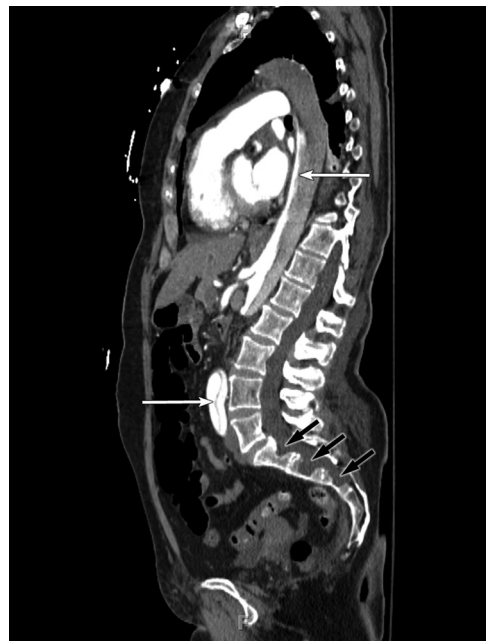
Dural ectasia as a sign of underlying connective tissue disease in aortic dissection. A sagittal CT scan demonstrates acute aortic dissection (white arrows) and dural ectasia (black arrows) in the lumbosacral spine of a woman with previously undiagnosed MFS.
